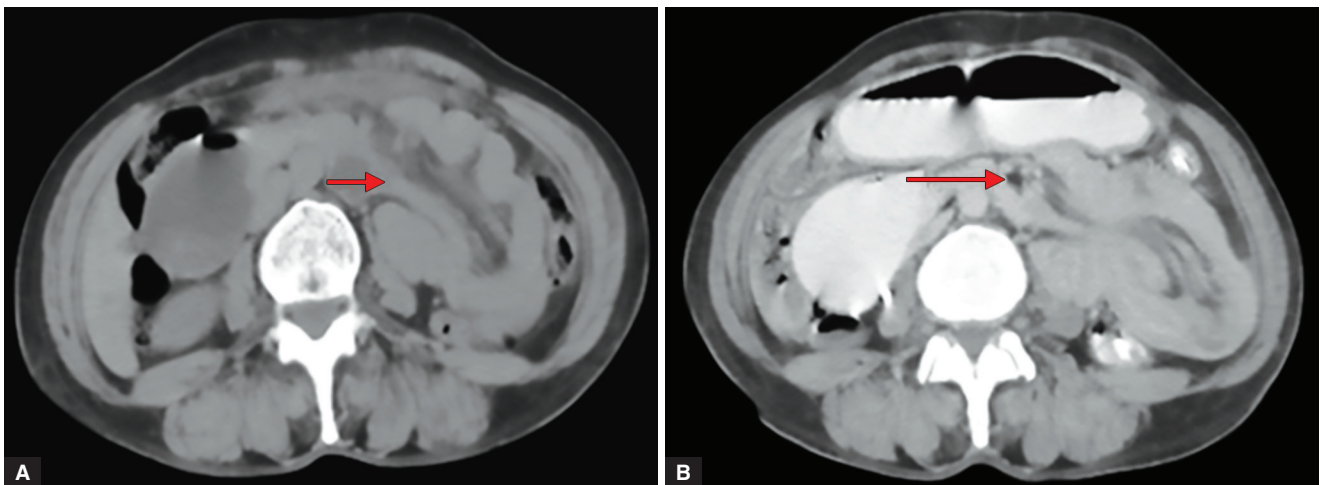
CT (A—plain) and (B—contrast) shows a long-segment intussusception in the distal ileum (short arrow), ileocecal junction, cecum, and proximal part of transverse colon secondary to an enhancing intraluminal polypoid lesion (long arrow). Case 1: A 58-year-old female presented with acute pain abdomen
